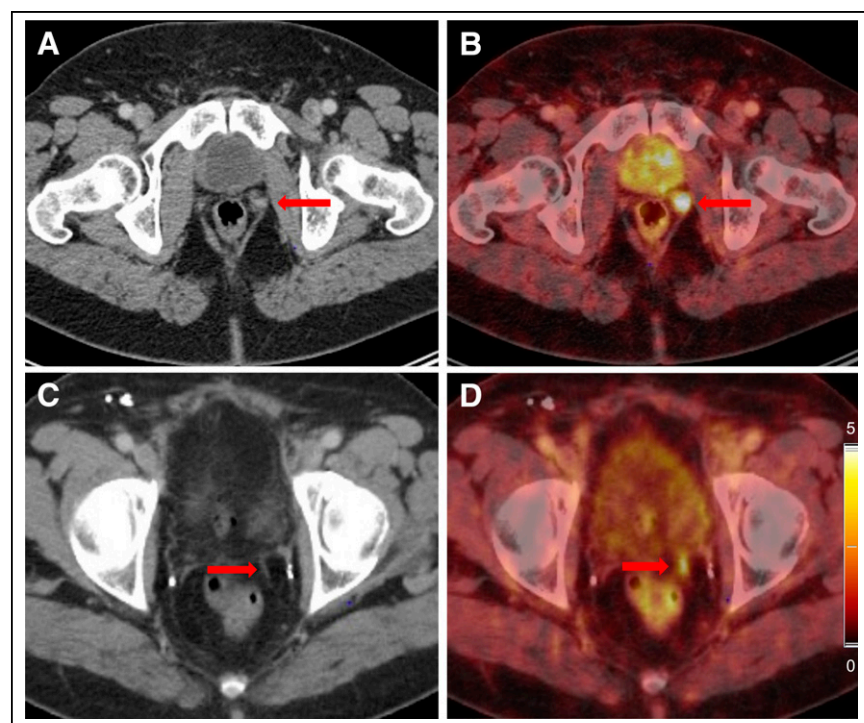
76-y-old patient presenting with local recurrence (arrow) near left seminal vesical bed before PSMA RGS (A and B). PSA level at time of PSMA PET/CT scan was 2.1 ng/mL. PSA nadir after PSMA RGS was 0.29 ng/mL. After RGS, PSA level increased to 0.5 ng/mL. PSMA PET/CT scan after 3 y showed local recurrence in left pelvis (C and D), which was located slightly above initial site of local recurrence.
